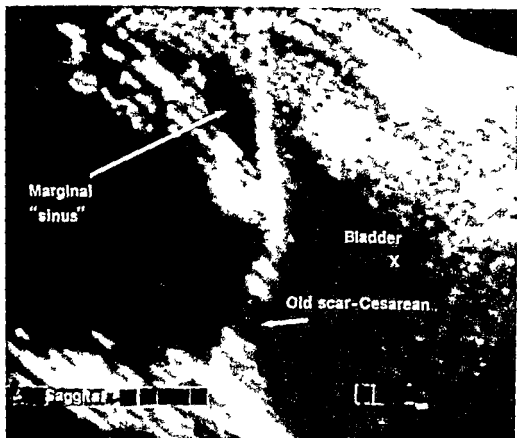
18 Sonogram showing intact marginal sinus or vascular channel in anteriorly located placenta with thinned scar from previous cesarean section
